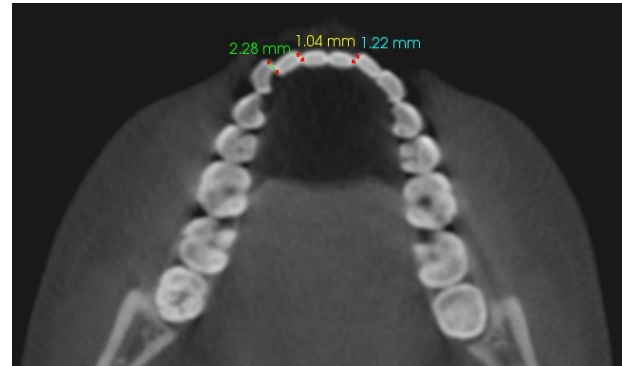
Analysis of Little's Irregularity Index using the axial section of CBCT.
